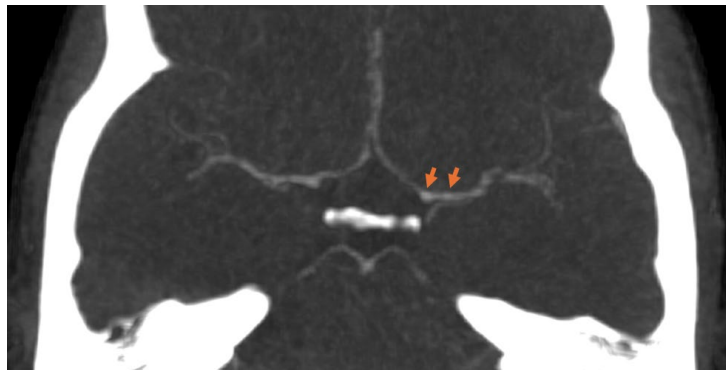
Cranial CT angiography, arterial phase, axial section, showing areas of flow narrowing alternating with preserved-caliber segments in the anterior, middle, and posterior cerebral arteries, resembling a “string-of-beads” pattern.
